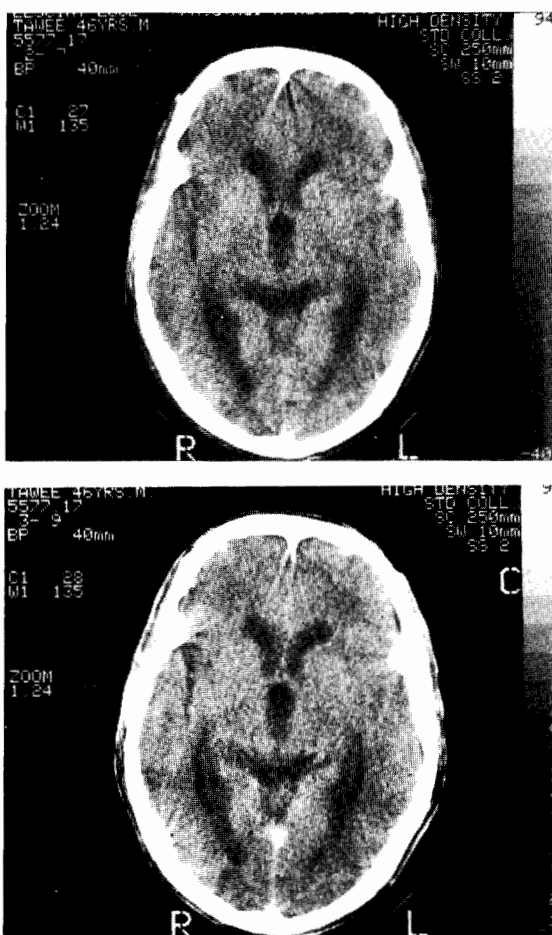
4 CT scan (pre and post contrast) showing dilated of 3rd ventricle.
